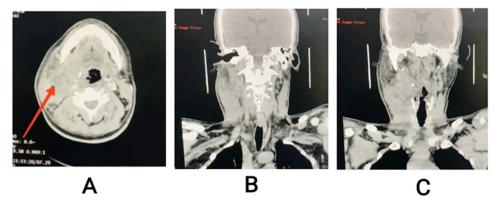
Contrast enhanced Computed Tomography of neck - Axial and coronal views
